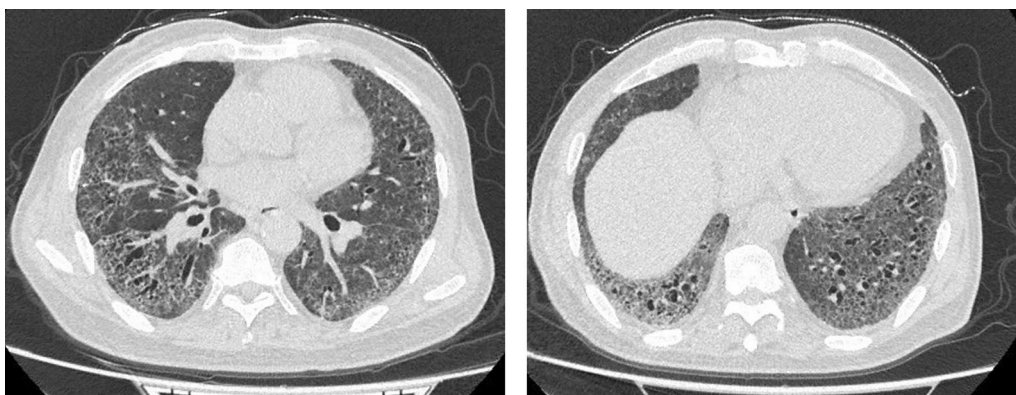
Chest computed tomography (CT) findings. Reticular septal thickening, worsened traction bronchiectasis, and newly appeared ground-glass opacities distributed along the bronchovascular bundle and in the subpleural area
